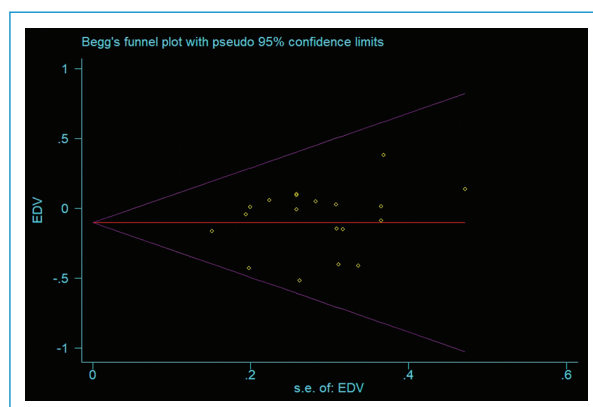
Funnel plot of publication bias for EDV (MRA vs. CTA), continuity corrected Begg's p 0.726.
